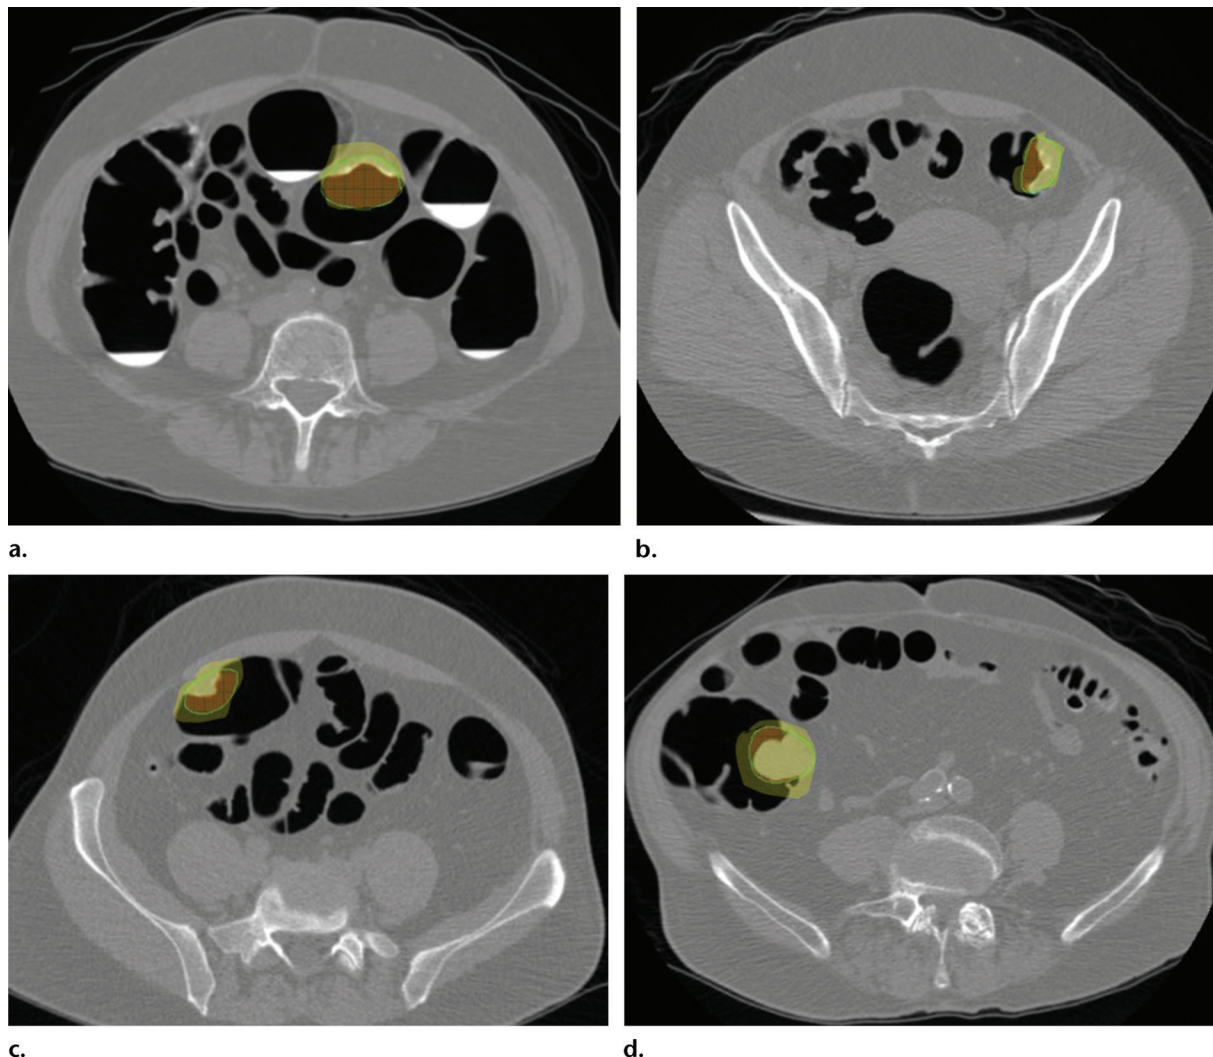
Texture analysis for distinguishing benign from malignant colorectal masses. Images from CT colonography show colorectal masses (highlighted in color) that were segmented semiautomatically for volumetric texture analysis. (a, b) Sigmoid masses: benign tubulovillous adenoma with high-grade dysplasia (a) and invasive adenocarcinoma (b). (c, d) Cecal masses: benign tubulovillous adenoma with high-grade dysplasia (c) and invasive adenocarcinoma (d). At subjective evaluation, at least one of the three readers misclassified a mass as benign or malignant in three of these four cases (all but b).
